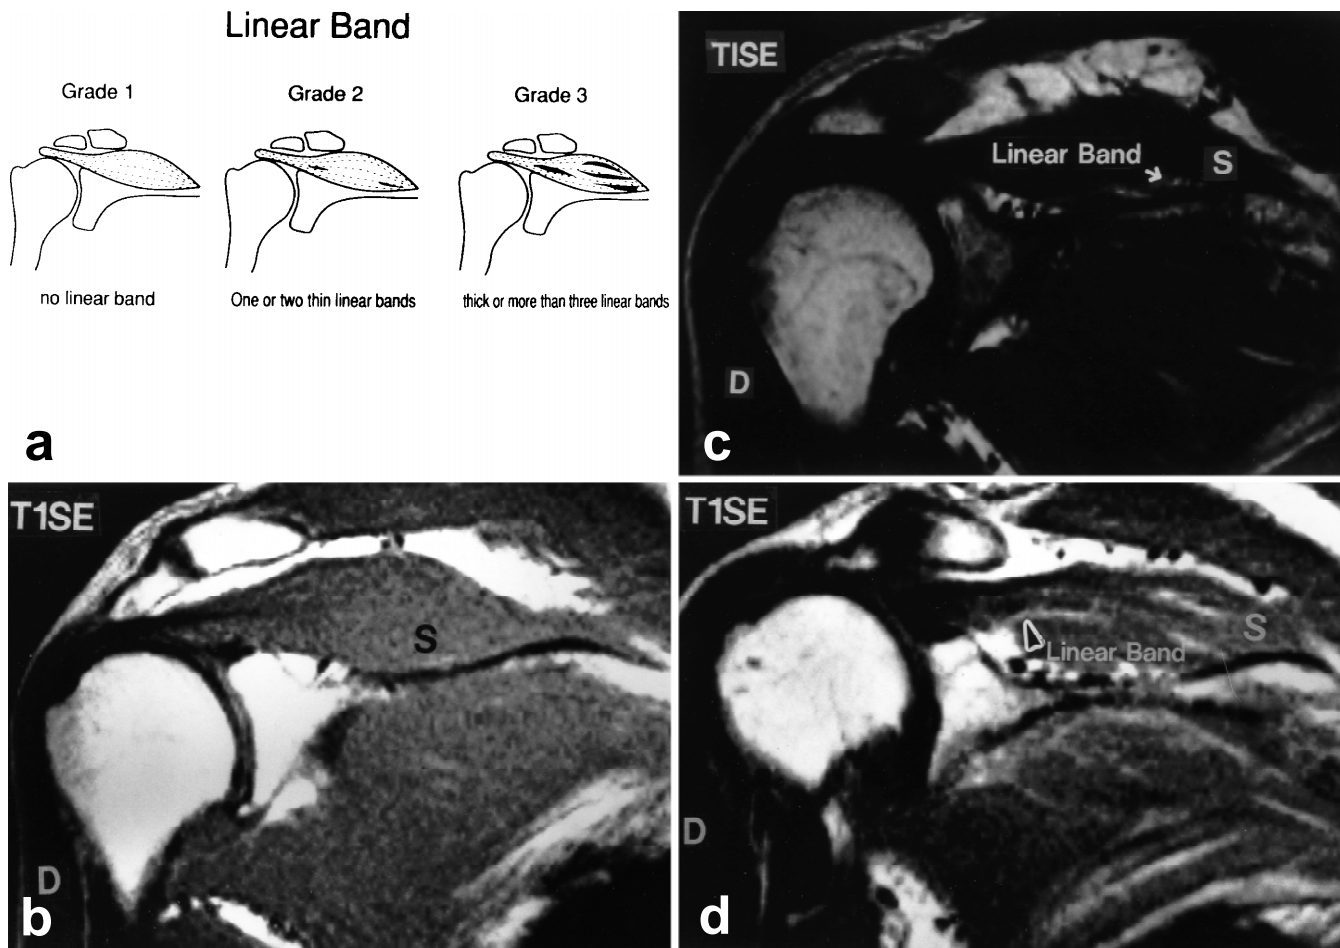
Classification of linear bands: T1-weighted image. S, supraspinatus muscle; D, deltoid muscle. a Grades of linear band appearance: Grade 1, no linear band; Grade 2, presence of 1 or 2
